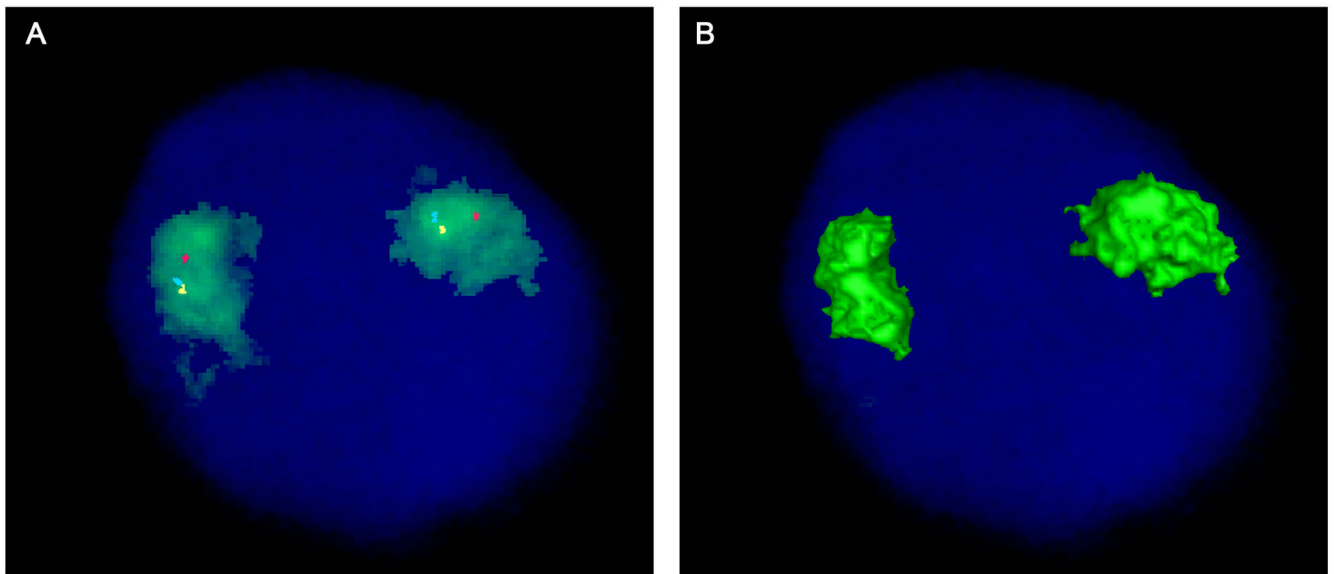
Four-color FISH showing chromosome 10 territory (green) and location of *RET* (blue pseudocolor), *NCOA4* (yellow pseudocolor) and *H4* (red). A. All three genes, *RET*, *NCOA4* and *H4*, are positioned within the chromosome 10 territory and away from the CT edge. B. 3D rendered image showing no signals on the surface of the CT due to the gene positioning inside the CT.
